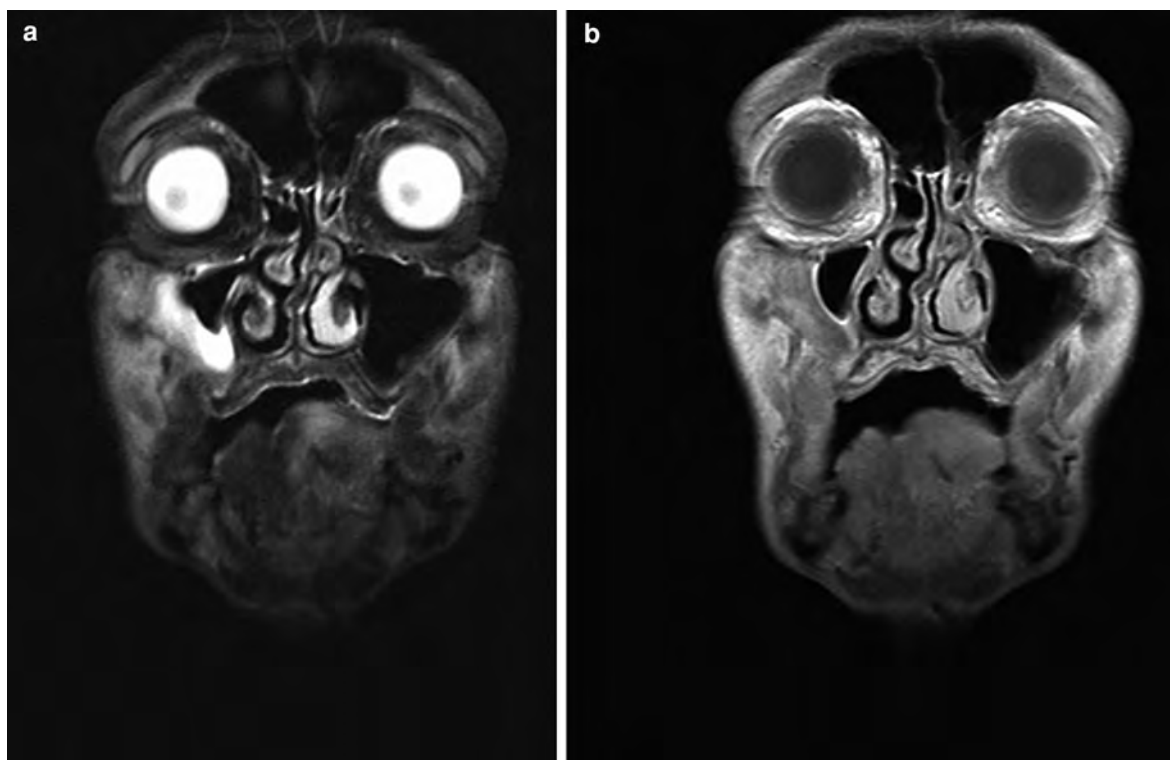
Coronal MRI of a 50-year-old male with a local recurrence at the *left* tongue. Both, the T2-weighted (a) as well as the T1-weighted post-contrast (b) images show a hyperintense lesion
